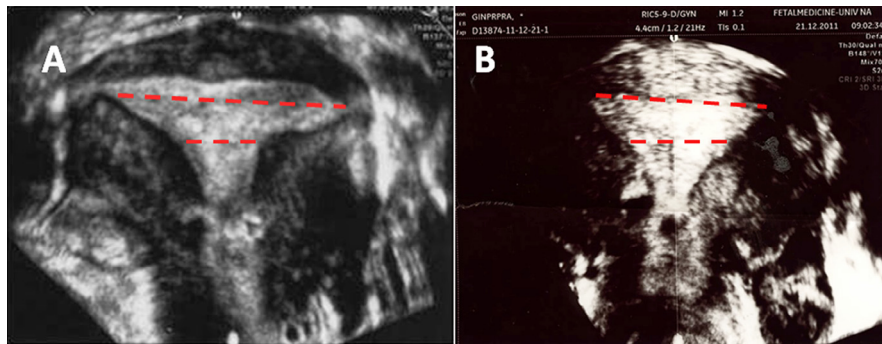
Three-dimensional transvaginal sonography showing an improvement of the volume and morphology of T-shaped uteri before (A) and after (B) the HOME-DU technique. An increase of the I/IO ratio was detected. I = isthmic diameter; IO = interstitial distance.
